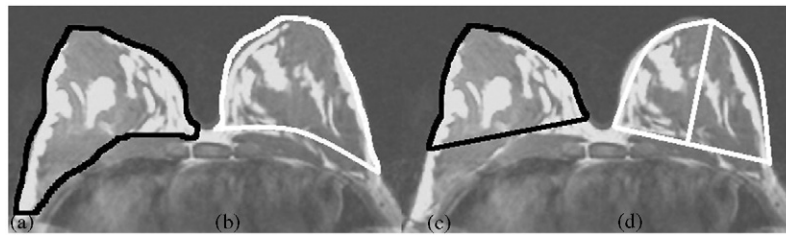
Example of breast volume areas measured in cc using the four different techniques. Measured areas are indicated by black and white lines on the two identical images: (a) MRI, (b) 3D scanning, (c) thermoplastic casts, and (d) modified anthropomorphic measurement with half-ellipse.
